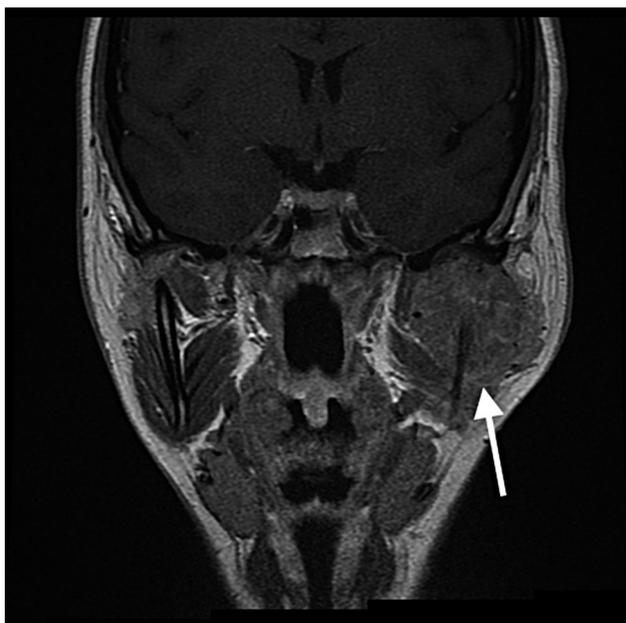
Coronal MRI scan showing the left mandibular metastasis (white arrow).
